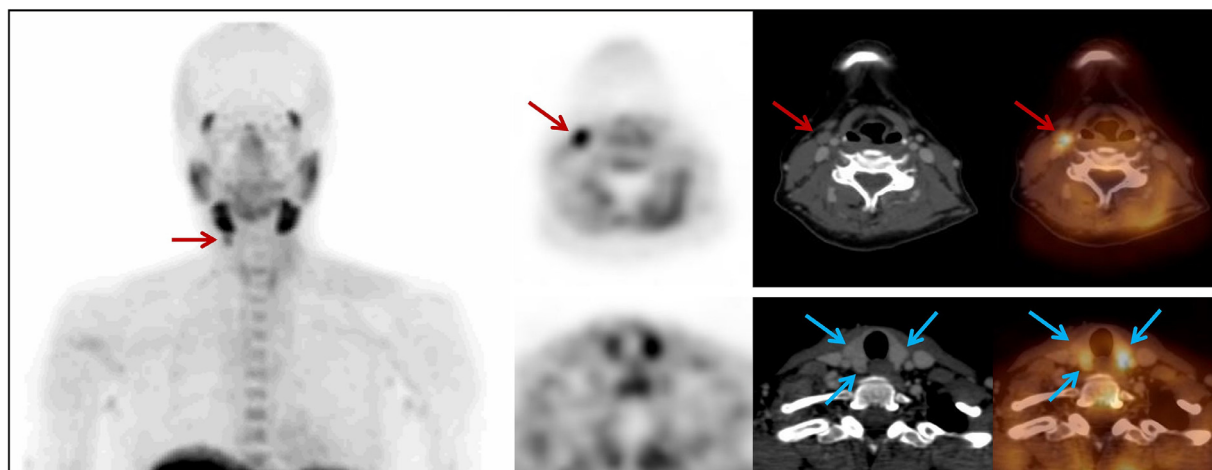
^{18}F -fluorocholine PET/CT in 36 year-old asymptomatic woman with mild elevation of serum parathyroid hormone level, mild hypercalcemia, and low serum vitamin D3 levels. Uptake of FCH by reactive cervical lymph node on the right side of the neck confirmed by cytology (SUVmax 3.5), potentially mimicking ectopic nondescended right inferior HFPTG, and by thyroid nodules (SUVmax 2.3 in the right lobe and 2.7 in the left lobe). Localization of lesions, their pattern on low dose CT image and biological context were helpful in yielding a correct interpretation of images. Moreover, higher significantly increased serum parathyroid hormone level would be expected in case of FCH avid hyperfunctioning parathyroid gland of 20mm in largest diameter, which was not the case of this patient.
